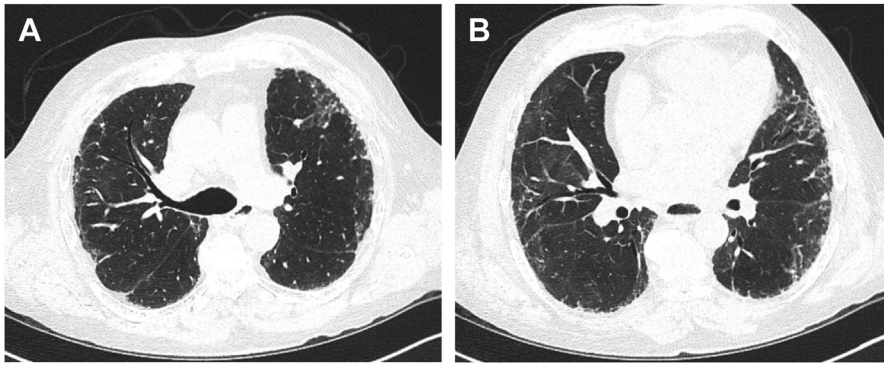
CT chest scan 5 months after COVID-19 pneumonia in the same patient presented in Fig. 1. (A) Subpleural peripheral reticulations seen in the bilateral upper lobes. Traction bronchiectasis in left upper lobe takeoff; (B) Peripheral GGOs with reticulation in bilateral lower lobes. These findings seem to represent fibrotic lung disease.
